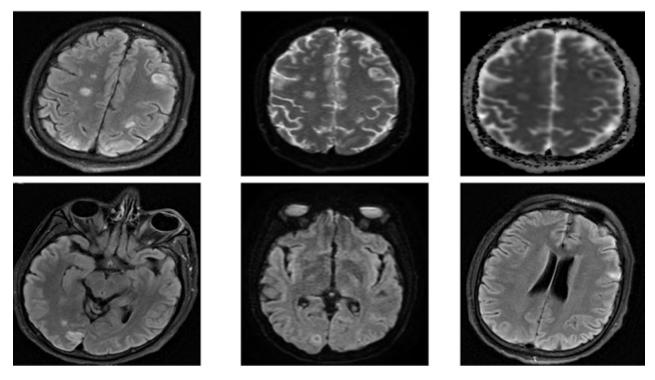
MRI showing multiple infarcts over left frontal, right parietal and right occipital region.
